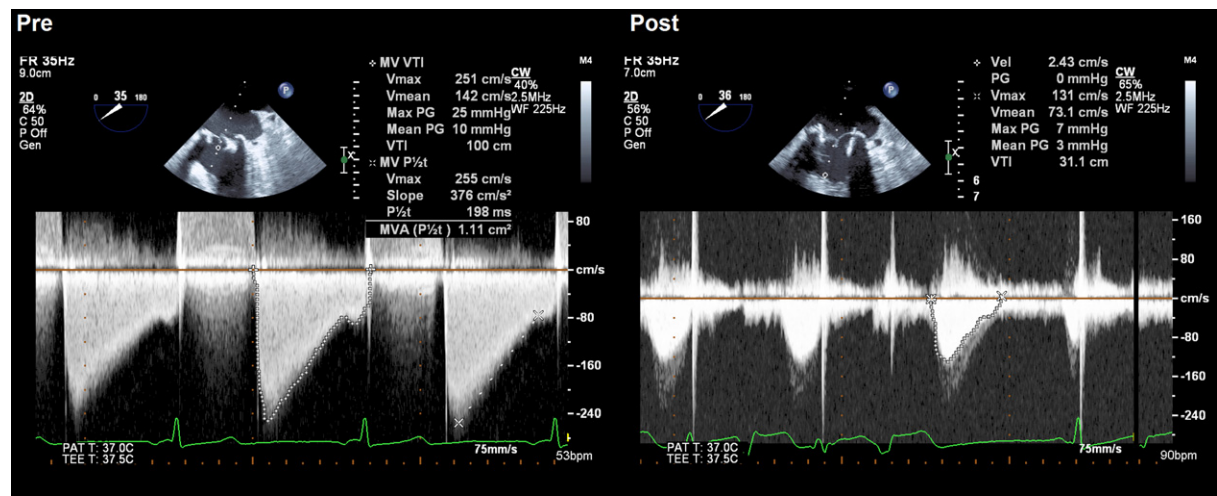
Doppler Continuous Transesophageal Echocardiogram
